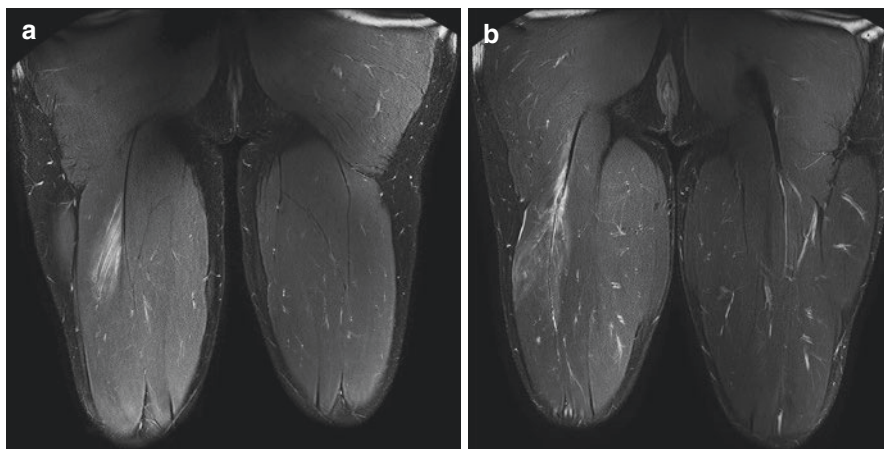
Magnetic resonance imaging (MRI) of an intramuscular tendon injury. Coronal STIR images demonstrating right-sided increased signal intensity in a feather-shaped pattern located in the proximal BF (long head). Panel (a) depicts a muscletendonous injury without intramuscular tendon injury. Panel (b) depicts an injury with partial-thickness intramuscular tendon injury, as evidenced by increased intratendinous signal intensity, intramuscular tendon disruption, and tendon waviness
